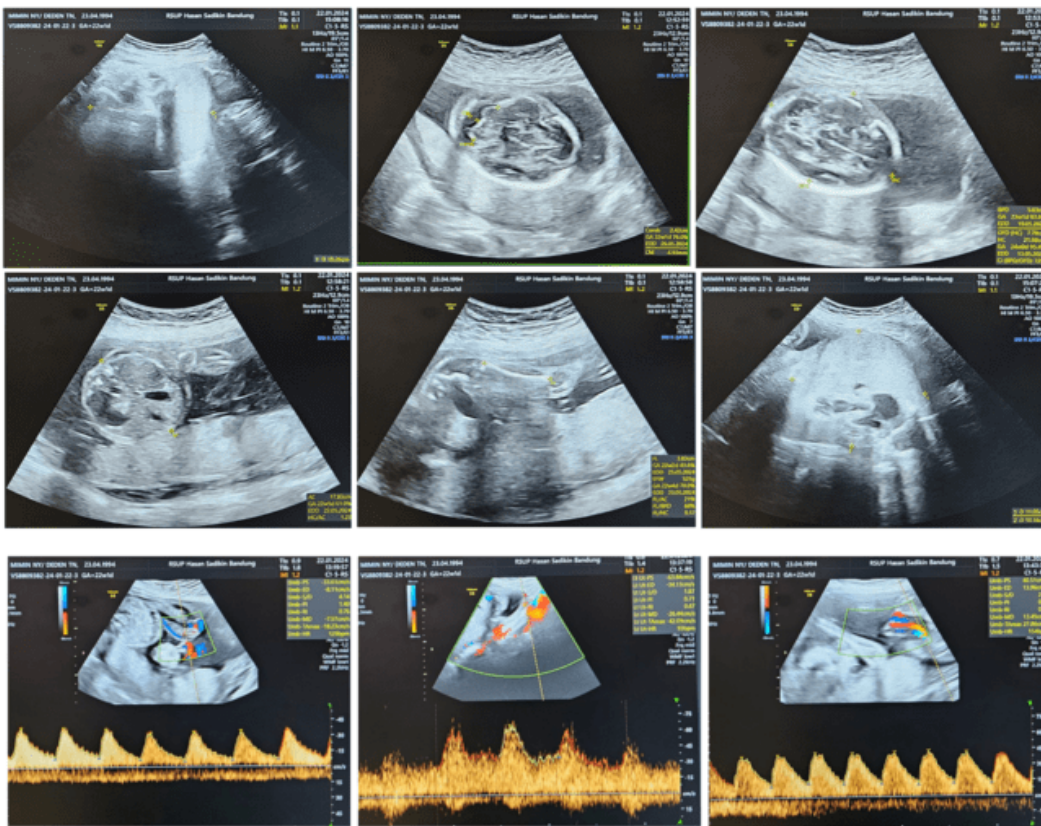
Fetomaternal Ultrasonography
